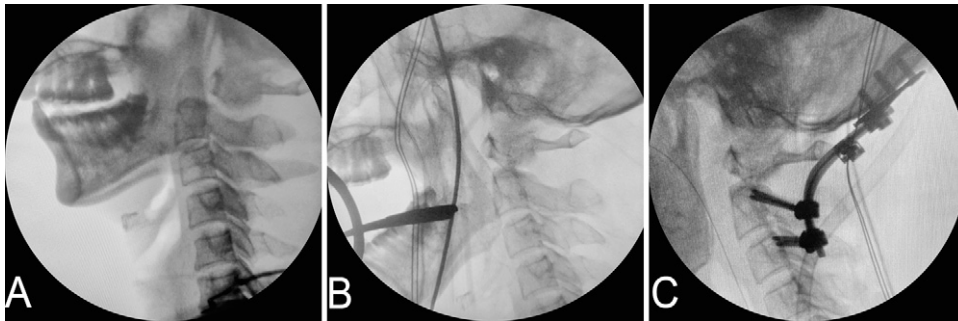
Intraoperative X-ray fluoroscopy showed posterior dislocation of the atlas (A). After odontoidectomy and manual traction were attempted, the posterior dislocation of the atlas had moved forward significantly, but no anatomical reduction had been achieved (B). To increase stability, posterior occipitocervical fusion was performed (C).
